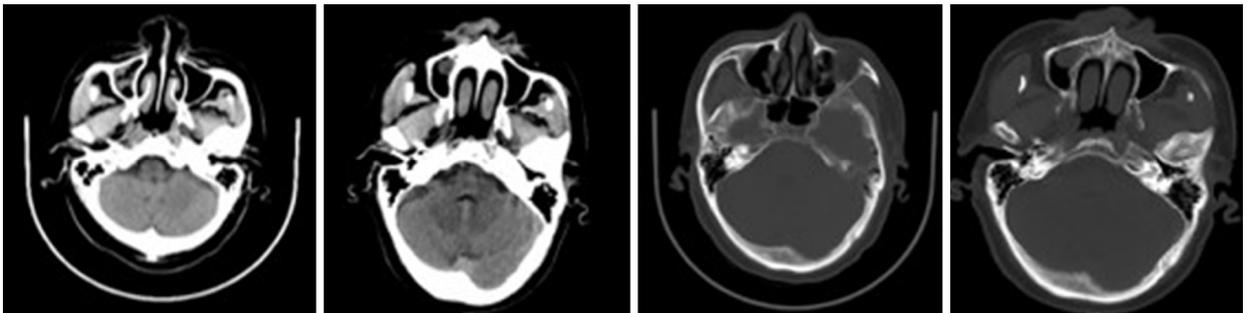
Physical examination (May 27, 2016). An axial head computed tomography scan showed a round soft tissue shadow under the mucosa of the maxillary sinus on the right side with a clear boundary.
